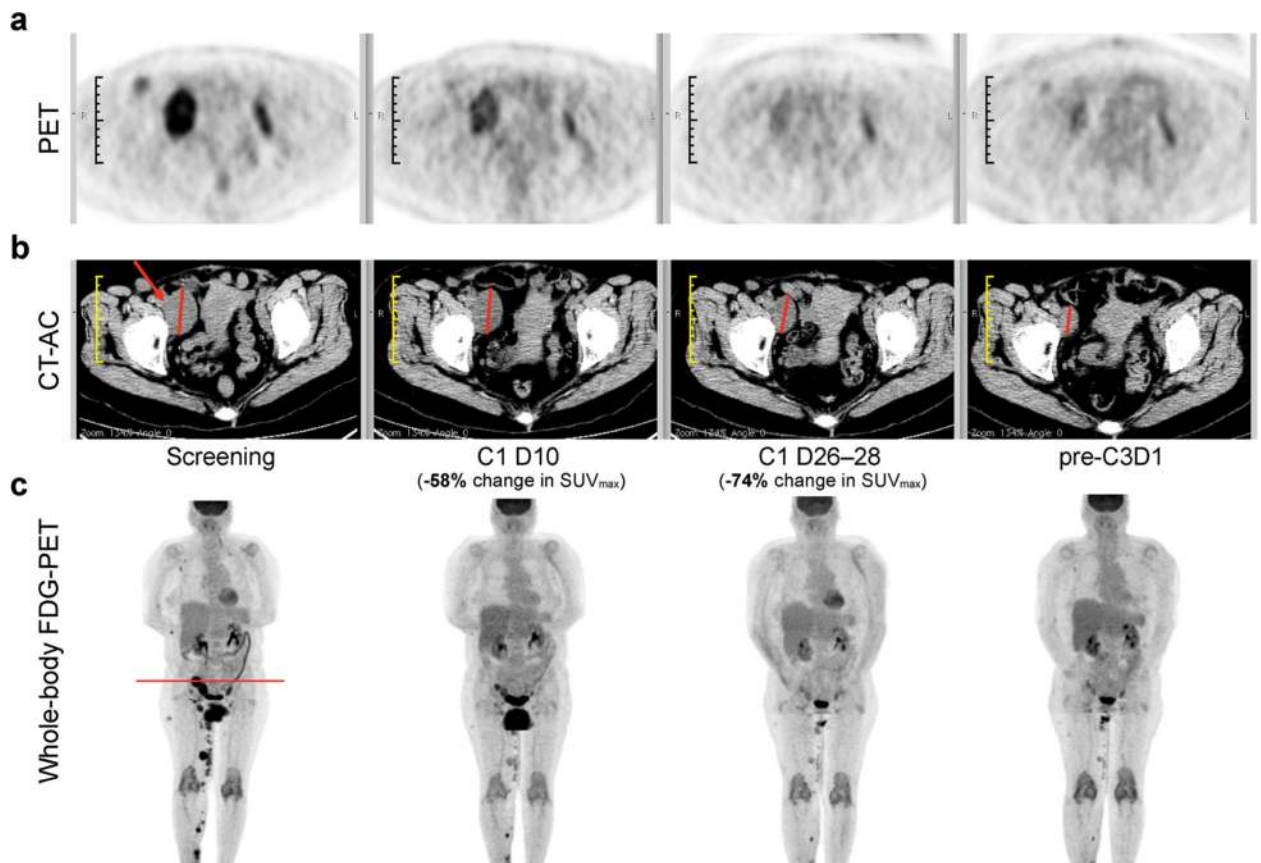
Cobimetinib anti-tumor activity in BRAF^{V600E} mutant melanoma, imaged using (a) PET, (b) CT-AC, and (c) FDG-PET. (a), (b) *Black* and *yellow* scale bars, 1 cm/tick. (b) *Red arrow* indicates the tumor; *red lines* indicate the diameter of the tumor. (c) *Red line* shows the location of the scanned cross-section. *C* cycle, *CT-AC* computed tomography-attenuation correction, *D* day
